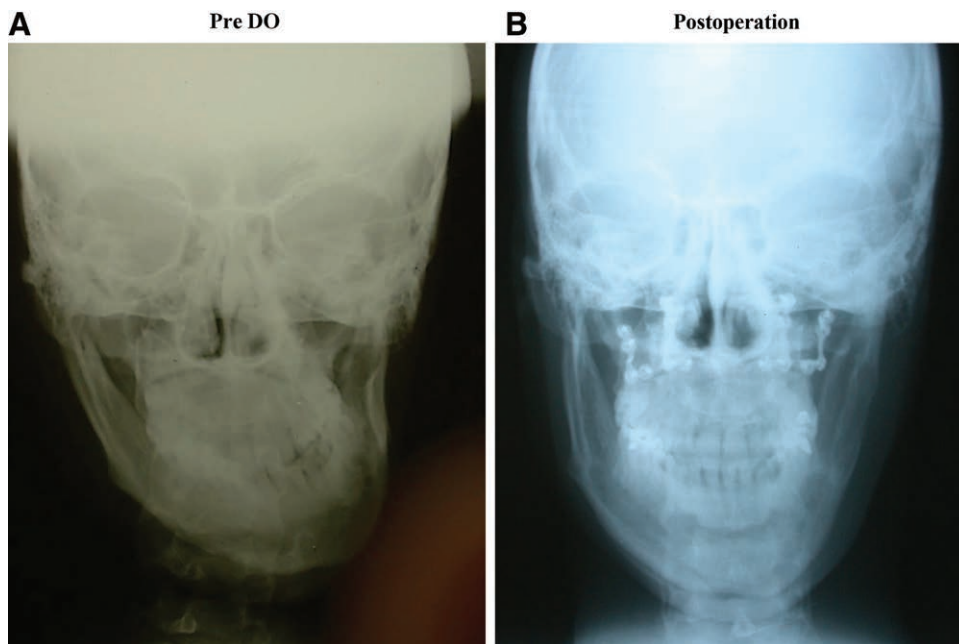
Radiographic surveillance. Pre (A) and post (B) surgical treatment posteroanterior cephalometric radiographs of the patient described in Figure 3 are presented.
